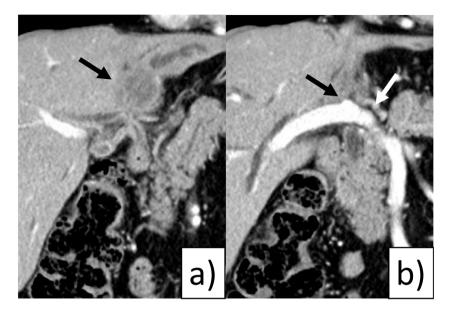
Coronal abdominal contrast-enhanced computed tomography showing a low-density mass at the hepatic hilum (a), involving the left main portal branch (b, arrows), with dilatation of intrahepatic bile ducts.
